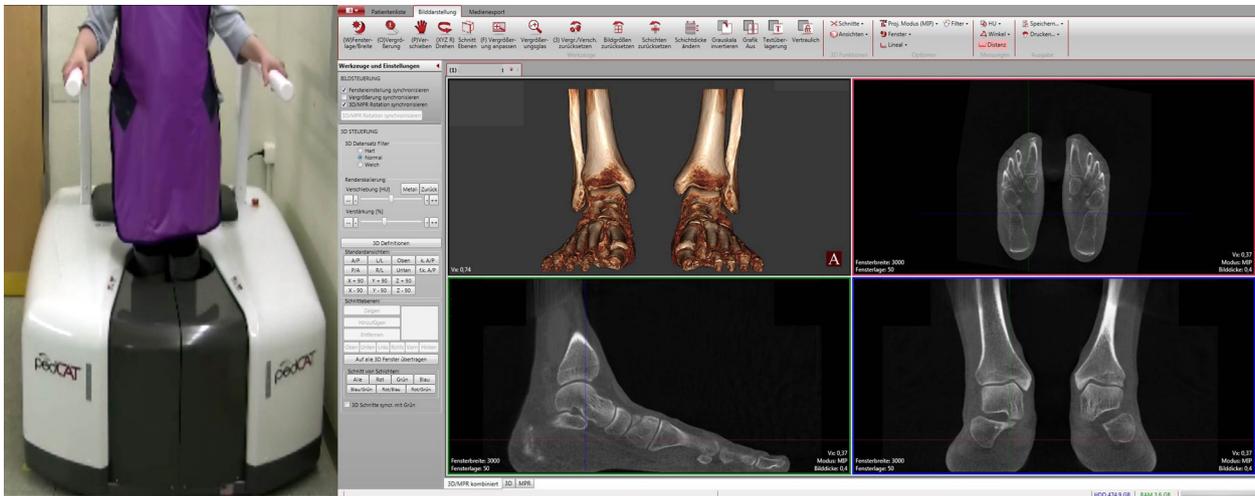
[17]. PedCAT-scan and software screen. An x-ray emitter and a flat-panel-sensor on the opposite side are rotating horizontally around the feet. Resolution and contrast which are the principal parameters for image quality are comparable with modern conventional CT. Left, patient positioned in pedCAT® during scan. Sitting position is also possible for patients that are not allowed or able to stand. The grey part is a sliding door that is opened before and after the scan. The patient can walk into the device of the door is open. Right, software screen view with 3D-reformation (top left), axial reformation (top right, red frame), parasagittal reformation (bottom left, green frame) and coronal reformation (bottom right, blue frame). The standard view is with 1 mm slice thickness, shown by the red, green and blue lines. The red lines are corresponding to the axial reformation in the red frame, the green lines are corresponding to the parasagittal reformation in the green frame, and the blue lines are corresponding to the coronal reformation in the blue frame.
